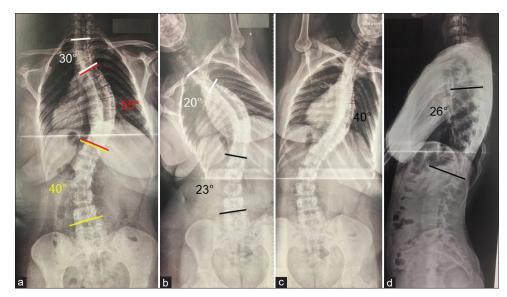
Spine radiographs of scoliosis patients. (a-d) Cobb angle measurements. (a) Posteroanterior radiograph with proximal thoracic (white lines), main thoracic (red lines), and thoracolumbar curves (yellow lines) measured. (b) Left-side bending radiograph showing proximal thoracic (white lines) and thoracolumbar flexibility (black lines). (c) Right-side bending radiograph showing main thoracic curve flexibility. (d) Lateral spine radiograph showing thoracic kyphosis measured from T5 to T12
